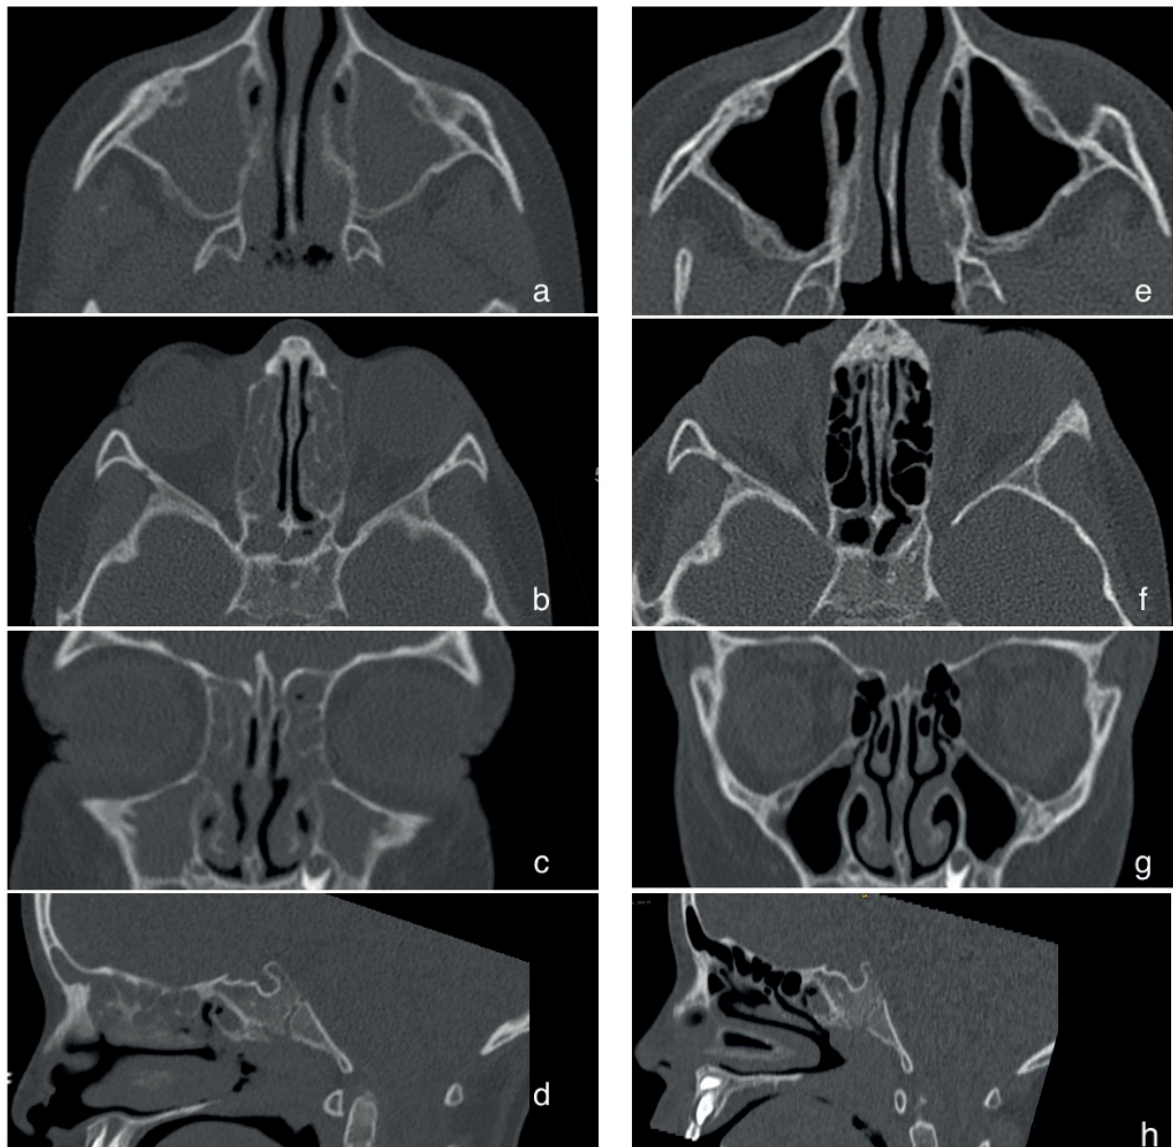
CT-scans in a patient before ETI initiation and after one year of treatment. Axials (a, b, e, f), coronal (c, g) and sagittal (d, h) CT-scan's slices before (a, b, c, d) and after 1 year of treatment with ETI (e, f, g, h) showing evolutions in maxillary (a, c, e, g), anterior and posterior ethmoid (b, c, d, f, g, h), sphenoid (b, f) and frontal (c, d, g, h) sinuses.
